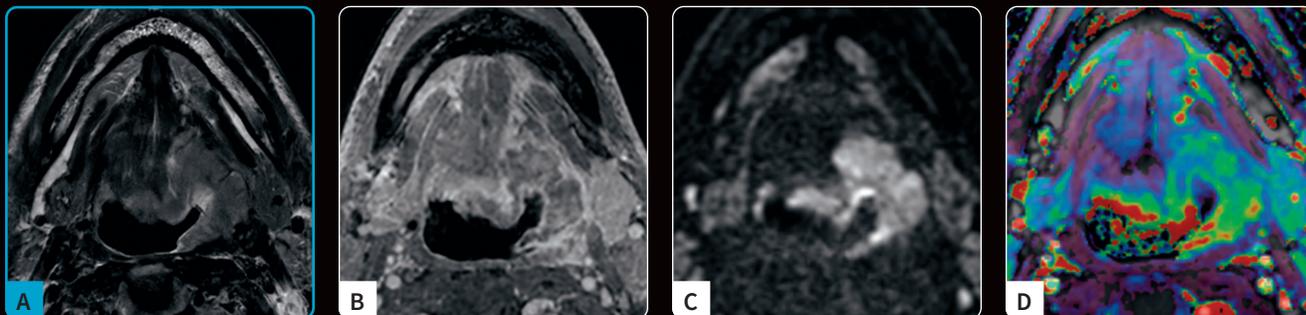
MR images of the base of the tongue in a patient with HPV-positive squamous cell carcinoma (SCC cT4a N0). Post processing was performed on GenIQ. (A) T2-weighted PROPELLER sequences with AIR Recon DL show an infiltration of the extrinsic muscles with the involvement of the lateral and posterior oropharynx wall. (B) T1-weighted FSPGR post-contrast shows the low enhancement of the tumor. (C) MUSE DWI shows a restricted signal intensity. (D) IAUGC (initial area under the gadolinium curve) map derived from DCE-MRI shows a hypovascular lesion.
